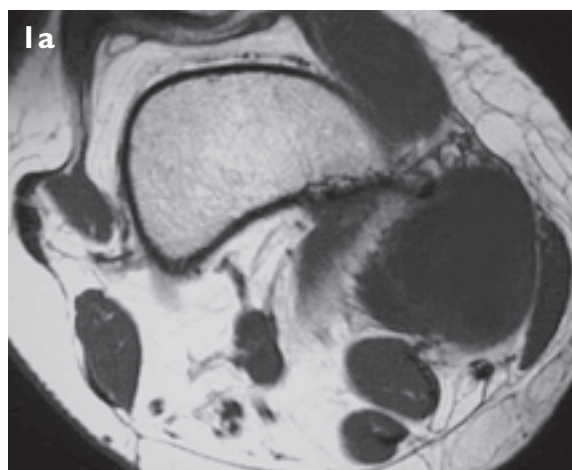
Axial (a) T1-weighted and (b) fat suppressed T2-weighted and (c) coronal T2-weighted MR images of the knee.
